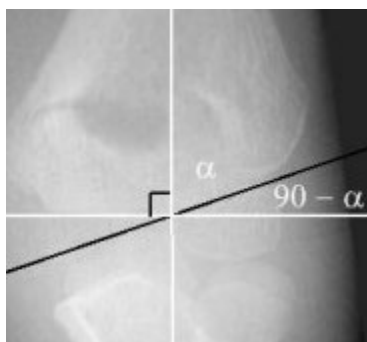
Baumann's angle on AP radiograph (Source: Wikipedia)
